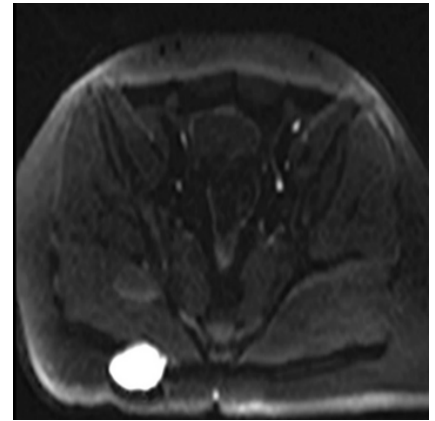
MRI T2-weighted imaging with fat suppression.
